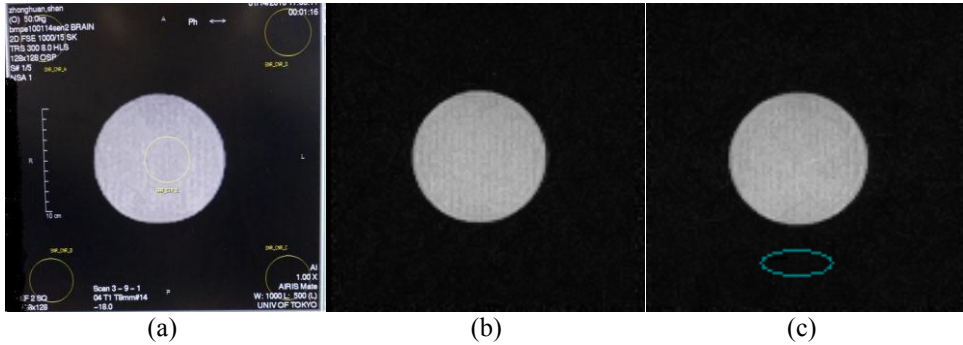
T1 weighted MR images, (a) without actuator, (b) with actuator power on. (c) The ellipsoid represents location of the actuator
